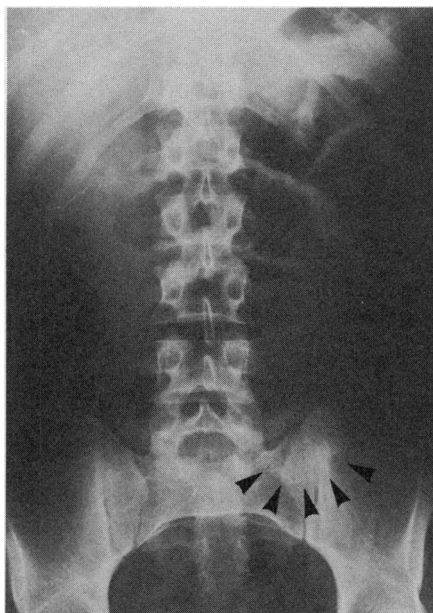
Radiograph showing several dilated loops of small bowel and circular density in the ileum on the left side of the abdomen.
